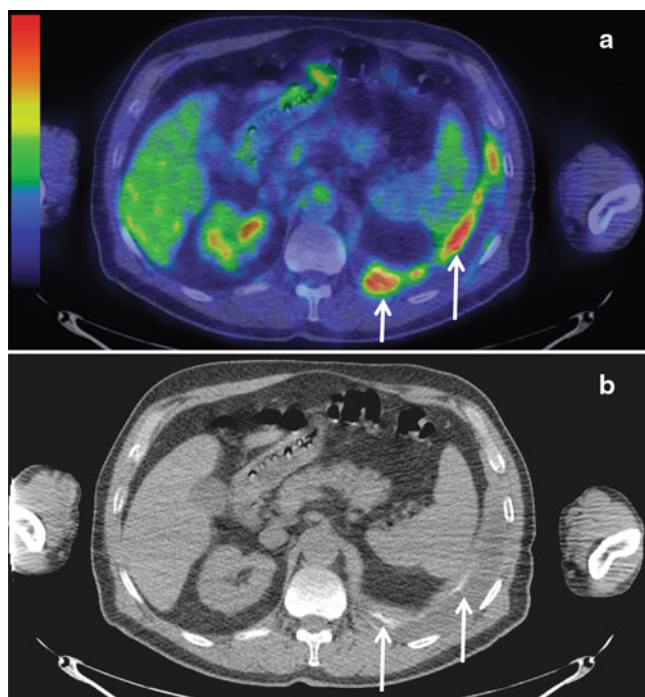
(a) A PET-CT scan demonstrating areas of increased FDG avidity at the left costophrenic angle. (b) The corresponding CT scan demonstrating talc (arrowed) at the sites of the increased avidity
